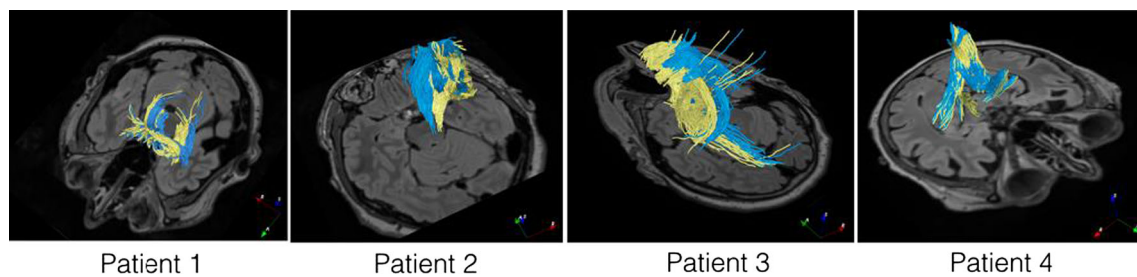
Demonstration of tractography deformation using tracts generated with tumor volumes as ROIs. Tracts before and after deformation are shown in yellow and blue colors. Axial T2 FLAIR MRI slices are added to help locate the tracts
